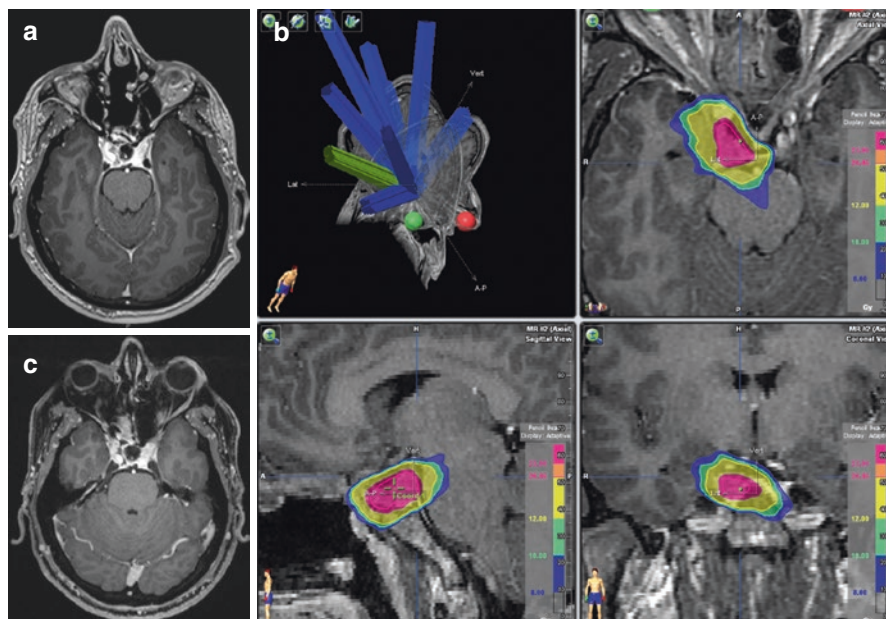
Growth Hormone secreting pituitary adenoma. (a) MRI before SRS. (b) Treatment plan SRS, Dose prescription 23 Gy periphery. (c) MRI 3 years follow up
